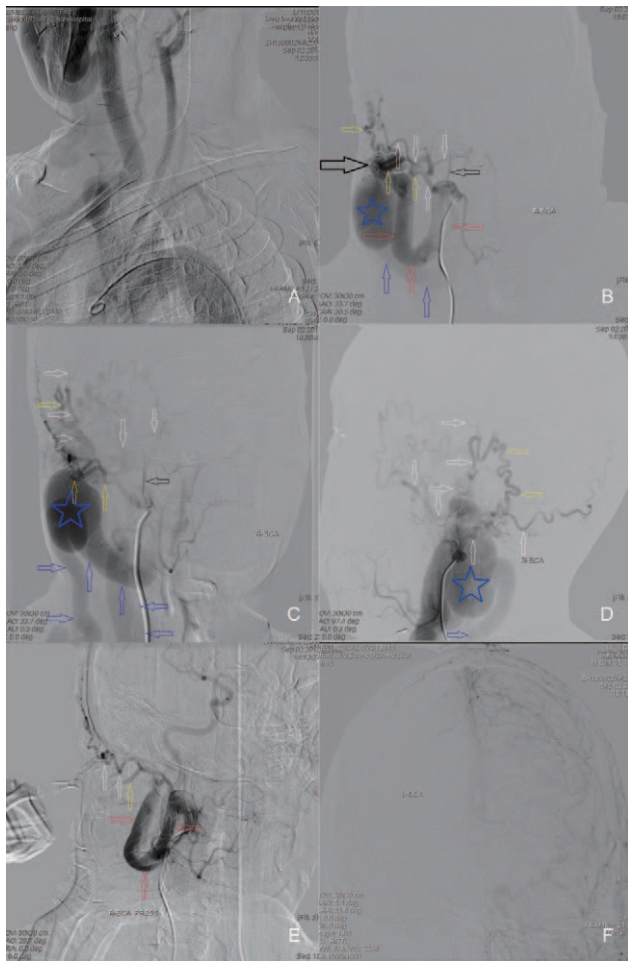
The patient underwent a following digital subtraction angiography. (A) The right common carotid artery, external carotid artery vascular system were remarkably thickened and tortuous. (B) There was a generous and irregular vascular mass (black “→”), popcorn-shaped in MRA, directly connected with the STA trunk just next to the root of internal maxillary artery (white “↓”). A gross U-shaped arterial loop (red arrow) appeared in ECA between the irregular vascular mass and the root of occipital artery (white “↑”). The ascending pharyngeal artery looks normal while the posterior auricular artery looks circuitous and thickened. There was a large venous lake (☆), the aqueous sac in magnetic resonance imaging, appeared in the regurgitant veins that adjoining to the irregular vascular mass. (C) The right STA (white “→”) and internal maxillary artery (white “↓”) were directly or indirectly supplying blood to the vascular mass and it was drained through ipsilateral common facial vein (blue “↑”) and external jugular vein (blue “→”), which appeared remarkably thickened and tortuous, and were further drained into the internal carotid vein (blue “←”) and the subclavian vein, respectively. (D) It was through much anastomosis the internal maxillary artery (white “↓”) and posterior auricular artery (yellow arrow) connect with the STA (white “→”) that beyond the irregular vascular mass and the blood in the STA trunk widens and centripetally flowed to the vascular mass, while the distal frontal and parietal branches of STA that beyond the anastomosis became very thin. (E) Right internal carotid artery appeared under enough pressure on the front of the tragus and would fleetly vanish without compression. (F) The blood supply of right copula scalp was partly fed by leftward external carotid artery. There was no blood from intracranial vessels and no contralateral external carotid artery flow to the fistulous mass. STA, superficial temporal artery.
